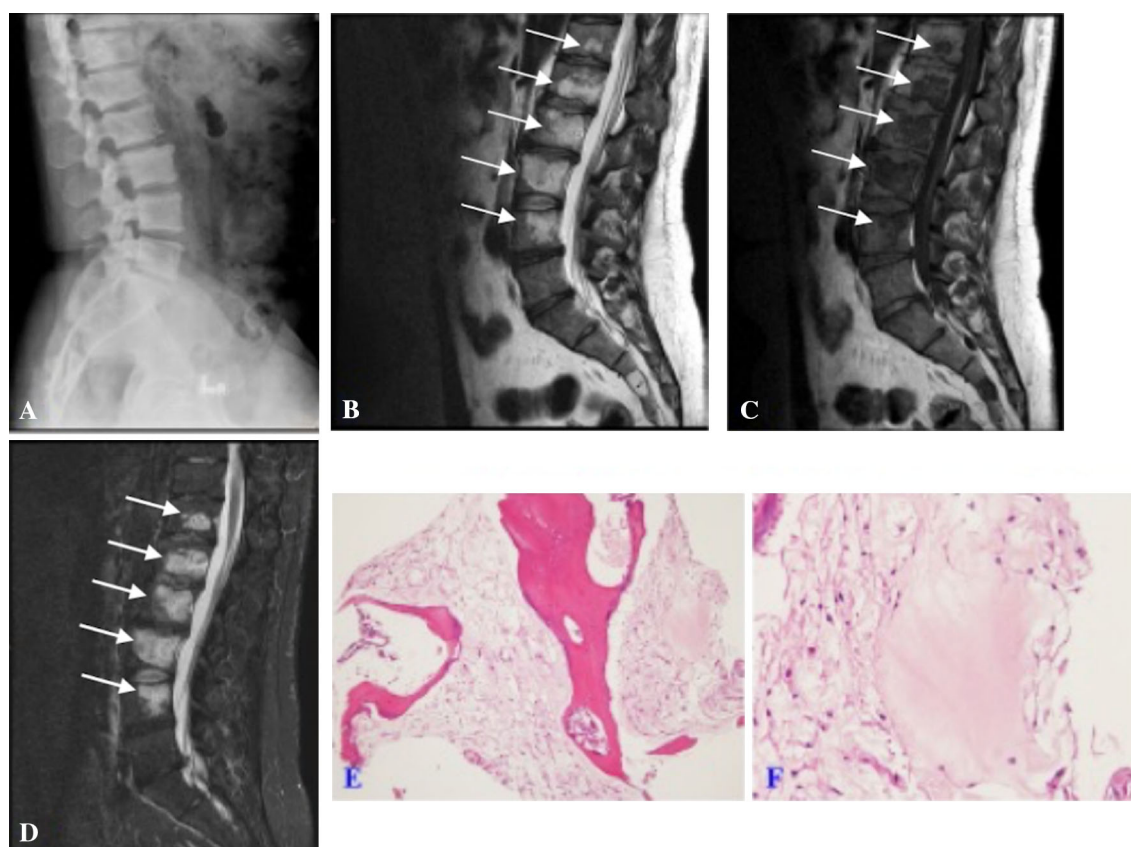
Radiographic examinations of the 29-year-old man. a Radiography shows decreased intervertebral disc height at the L5–S1 level. No osteolytic lesion can be found. MRI examination revealed multiple space-occupying lesions (arrows) with low signal intensity
